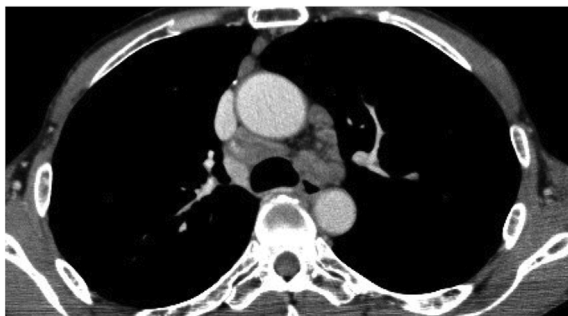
Computed tomography before endobronchial ultrasound-guided transbronchial needle aspiration. Enlarged mediastinal lymph nodes with calcification were observed.
